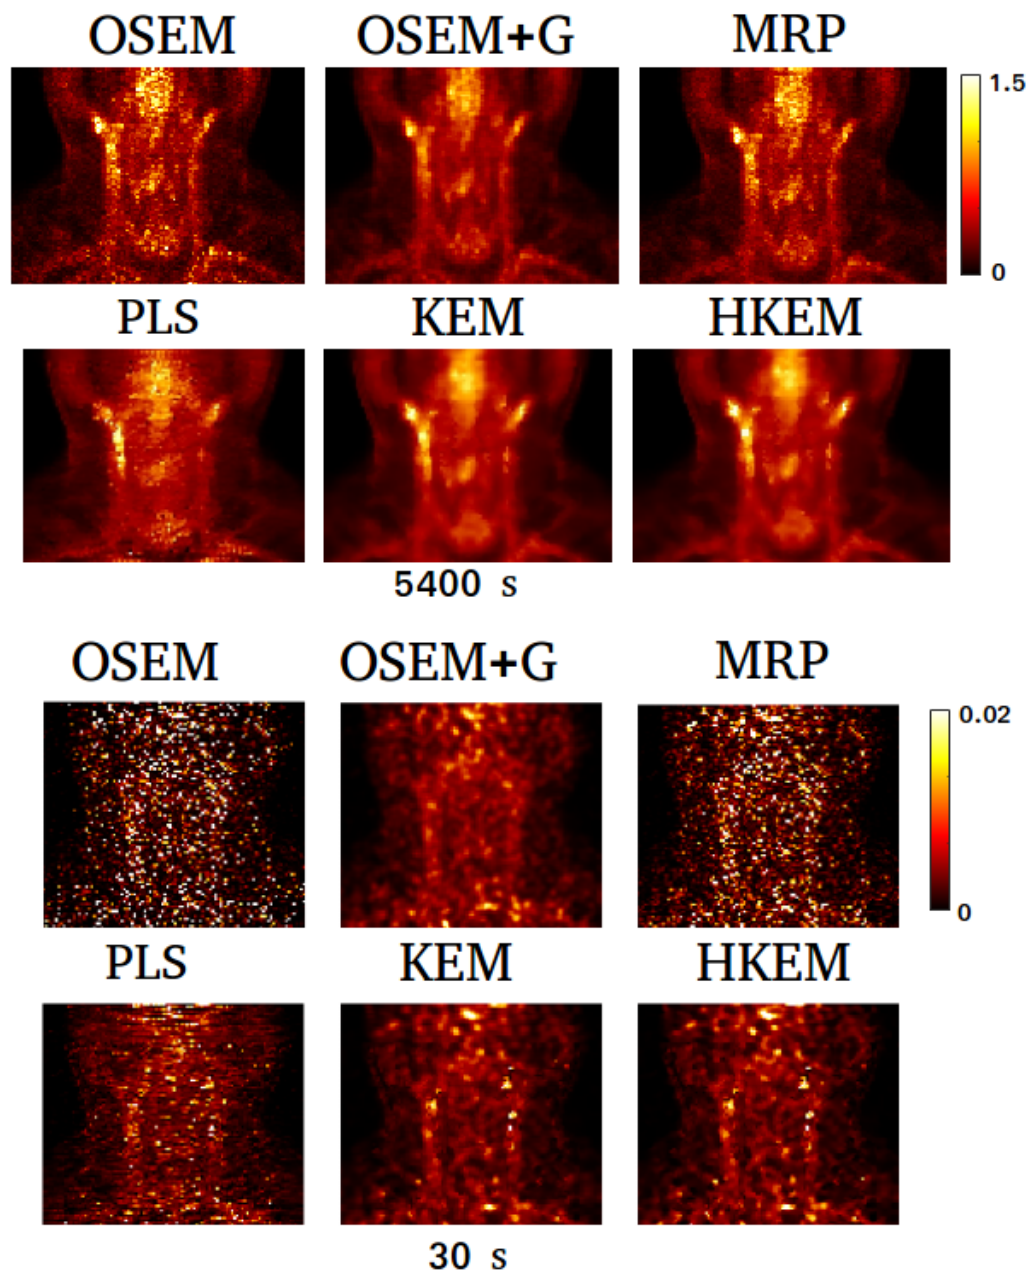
FDG study reconstructed images, at the  $3^{rd}$  iteration with OSEM, OSEM + 5 mm Gaussian post filter, MRP, PLS, KEM, and the proposed method HKEM. The figure reports in the top line the 5400 s acquisition, and in the bottom line the 30 s frame.
